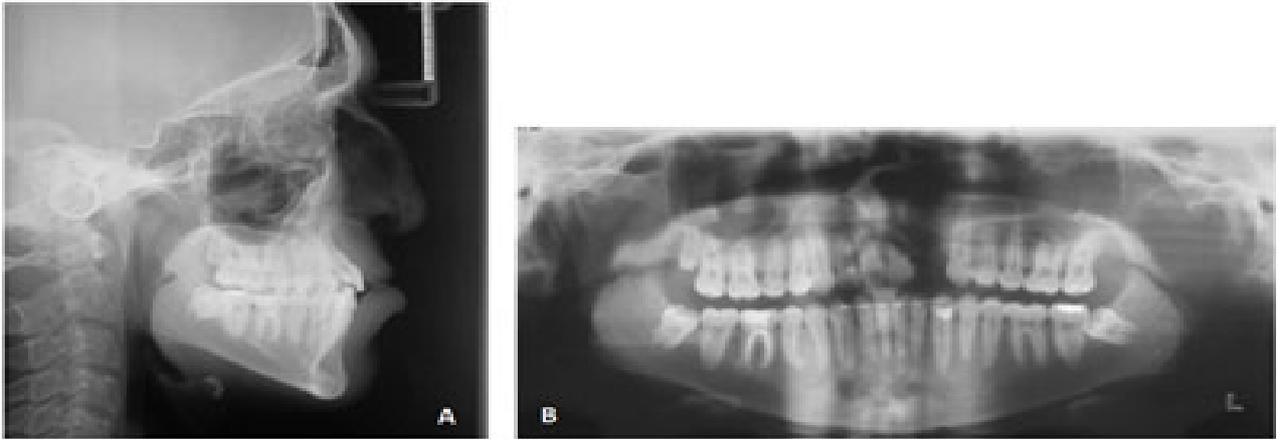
Post-treatment radiographs: Lateral cephalogram (A) and panoramic radiograph (B)
